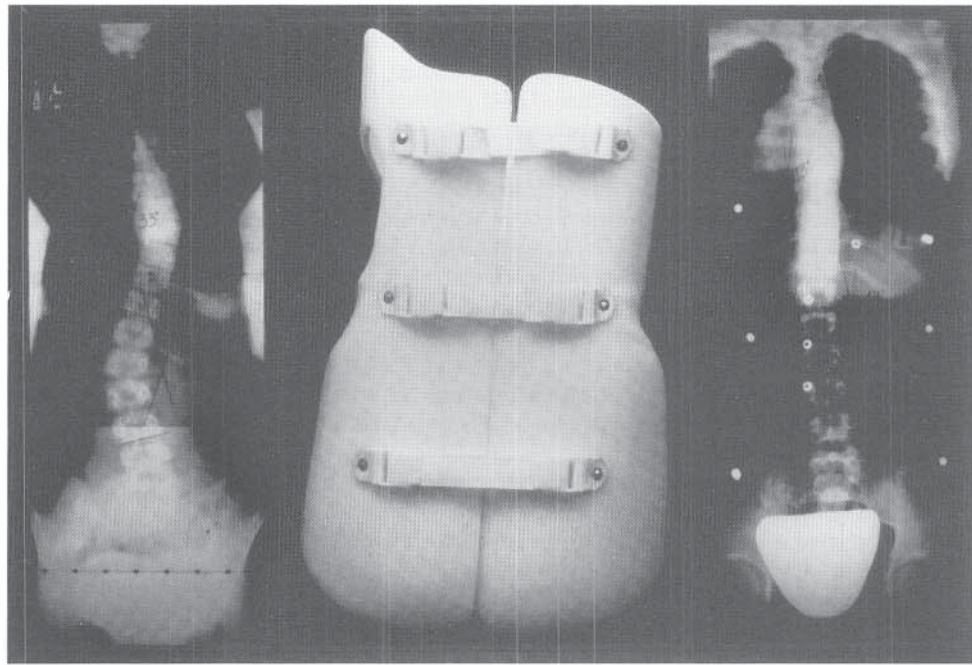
The Boston brace. This orthosis is a prefabricated, symmetric thoracolumbar-pelvic module with built-in lumbar flexion and areas of relief opposite areas of pressure. Each brace is individually modified based on the patient's full-length spine radiograph. This brace is the most common thoracolumbosacral orthosis used today.
